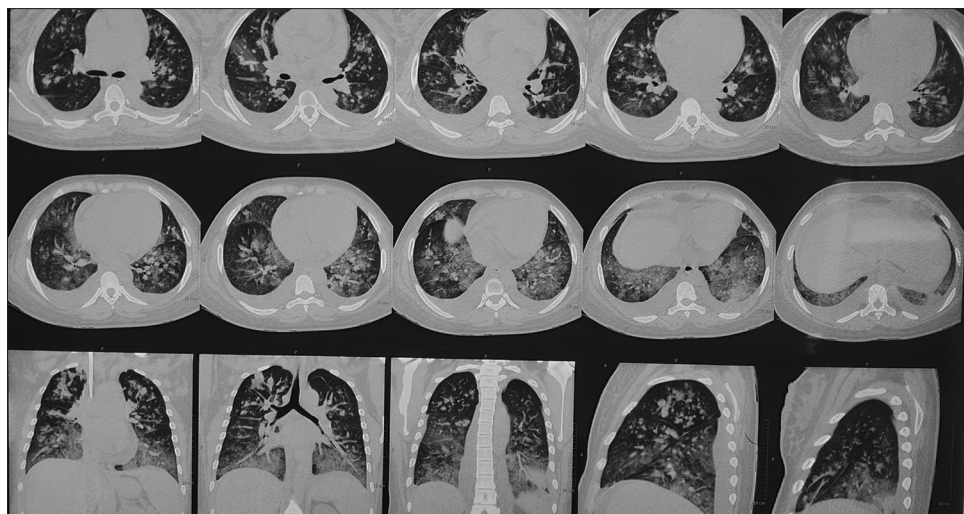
Non-contrast computed tomography (NCCT) chest showing multifocal patchy areas of consolidation with diffuse ground glass opacities in bilateral lungs, suggesting diffuse alveolar hemorrhage
